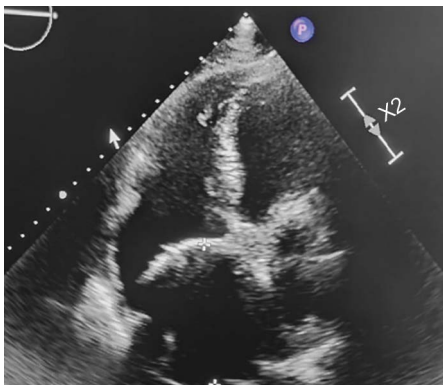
Four chamber view in echocardiography shows dilated Right atrium, with large cystic mass in it
